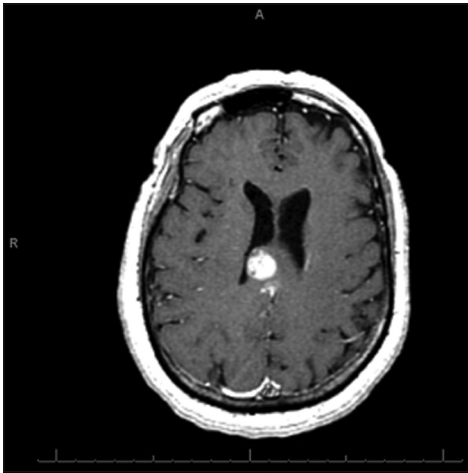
This T1-weighted axial magnetic resonance imaging scan with gadolinium contrast shows a homogeneously enhancing lesion involving the posterior corpus callosum and internal capsule crossing midline. A biopsy with varioguide showed WHO grade IV glioblastoma multiforme
